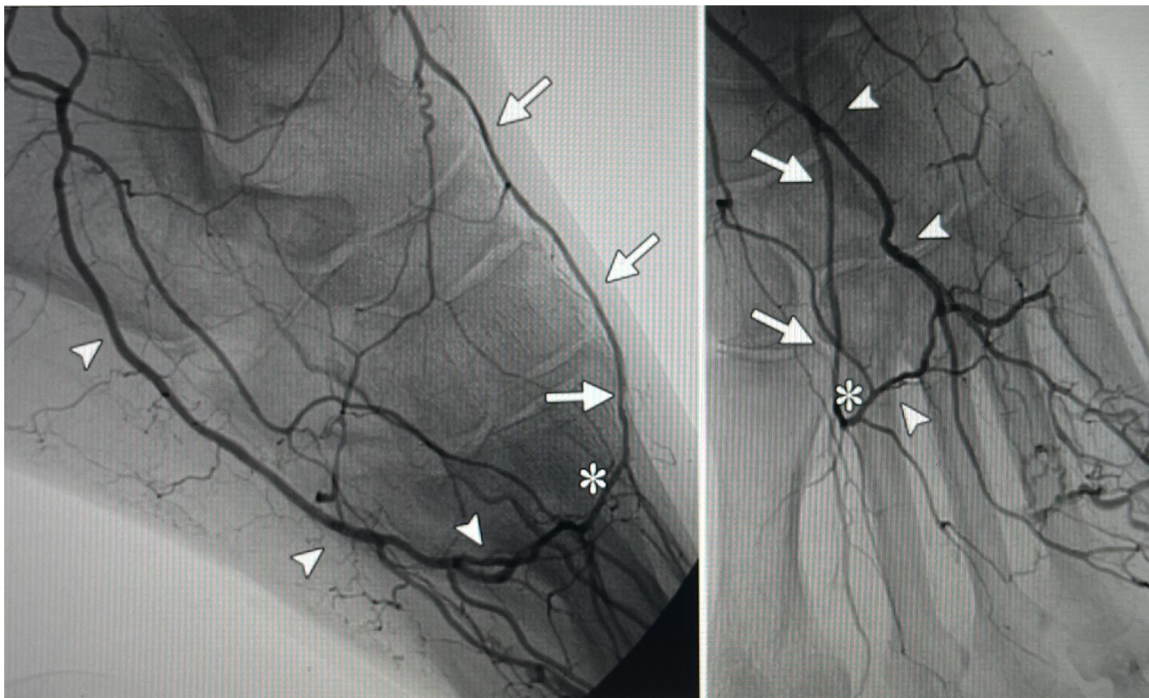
Lateral oblique view (left image) and anterior-posterior view (right image) show the pedal-plantar loop. The dorsalis pedis artery (arrows) is connected via the deep perforating artery (\*) in the first metatarsal space with the plantar arch and lateral plantar artery (arrowheads). From Manzi M, Cester G, Palena LM, et al. Vascular imaging of the foot: the first step toward endovascular recanalization. *Radiographics* 2011;31:1623–36 [22], adapted with permission.
